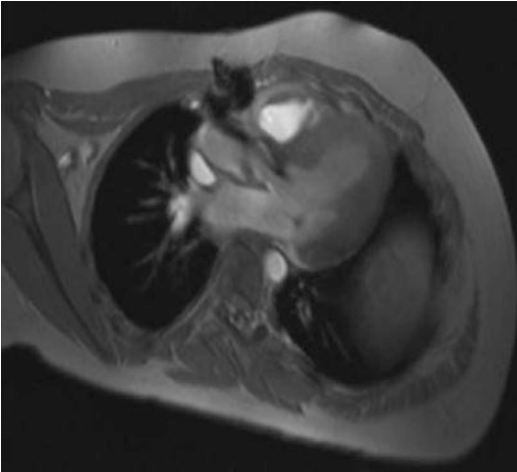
Posterior deviation of the outlet septum. Three-chamber view of cine FLASH MRI sequence image demonstrates a posterior deviation of the outlet septum creating subaortic stenosis. Note that the associated VSD is not well shown. The anomaly is associated with a left ventricular hypertrophy
